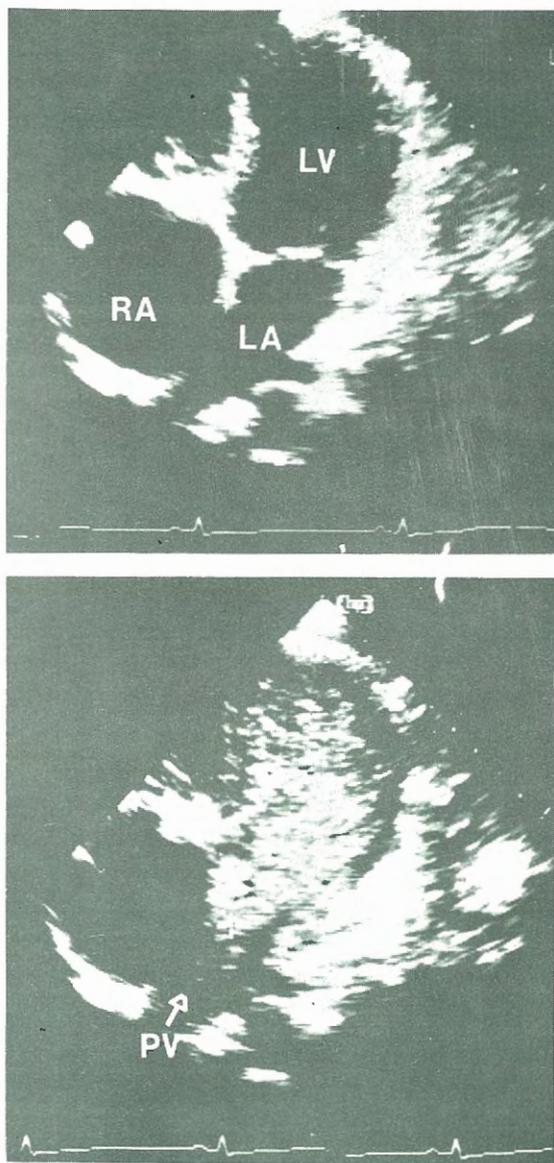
a) Two-dimensional echocardiogram from a patient with tricuspid atresia and a Glenn shunt (case 3), b) contrast medium fills the left atrium from the pulmonary veins, suggestive of PAVF. LA: left atrium, LV: left ventricle, PV: pulmonary vein, RA: right atrium.
